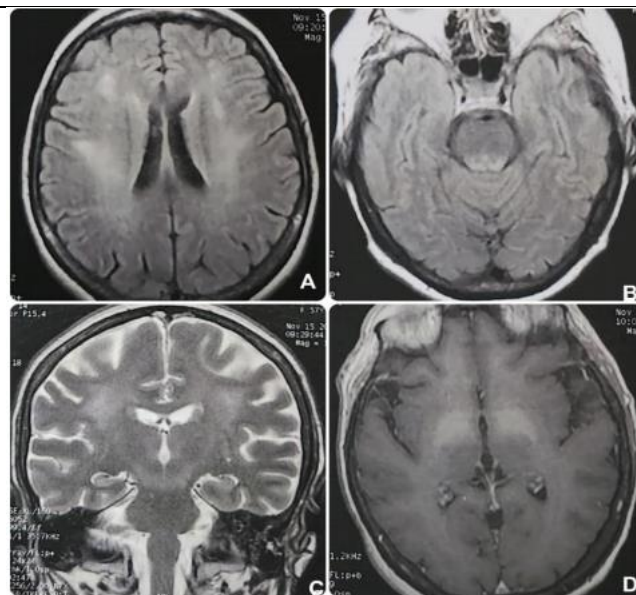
Periventricular and periaqueductal white matter hyperintensities noted in cerebral MRI in axial T2 FLAIR (A,B) and coronal T2 (C). Axial T1 sequence (D) demonstrates bilateral pallidal hyperintensity
